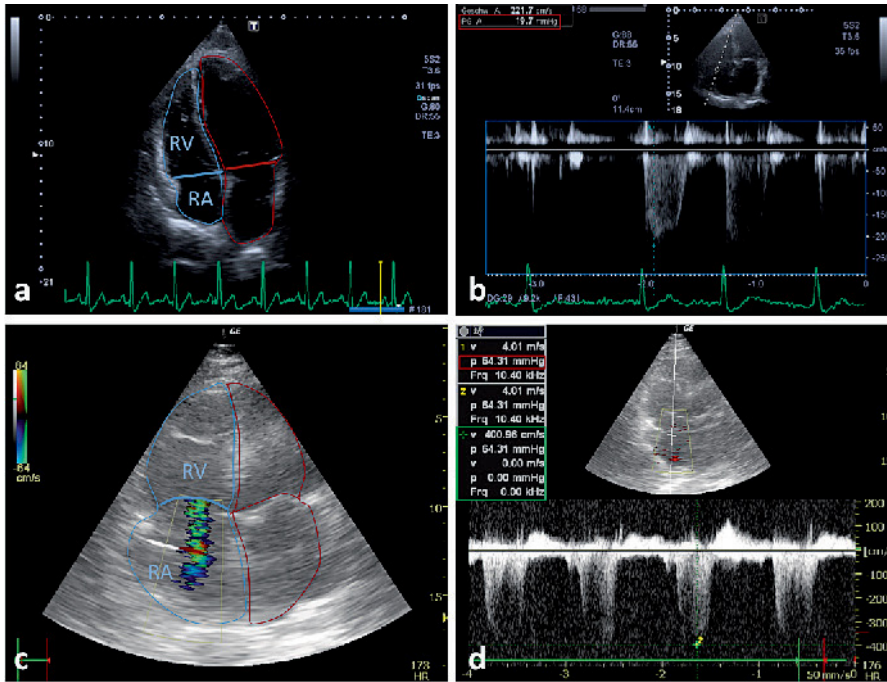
Heart failure on echocardiography. a) In the normal heart, the right ventricle (RV) and right atrium (RA) (blue) are smaller than the left heart chambers (red) and nestle into them. b) Continuous wave Doppler scanning allows us to determine the pressure in the right ventricle from the gradient across the tricuspid valve. 19.7 mm Hg is within the normal range. c) With a volume overload, the RA and RV (blue) are dilated. The right heart chambers are even larger than the left (red). Dilatation of the right heart also leads to tricuspid regurgitation (green). d) The measured gradient of 64.31 mm Hg across the tricuspid valve is abnormally high. Adding the central venous pressure of approximately 10 mm Hg gives a pulmonary artery pressure of about 75 mm Hg (normal < 30 mm Hg). If left ventricular function is also impaired, the pulmonary circulation becomes congested and pulmonary oedema threatens. The findings correlate with considerable clinical impairment.
